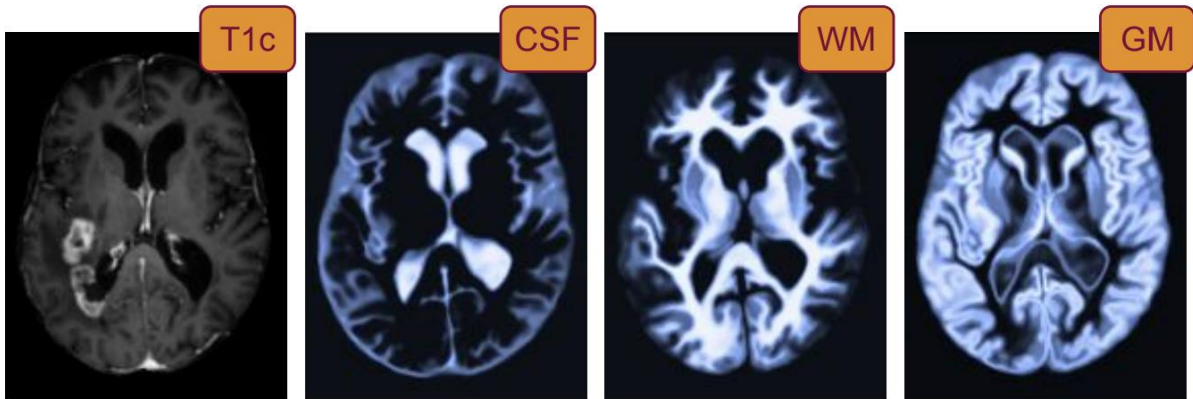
An example of probabilistic tissue segmentation (Cerebrospinal fluid (CSF), White matter (WM), Grey matter (GM)) and corresponding MRI T1c scan. The probabilistic segmentations offer information on the expected tissues underneath and nearby the tumor (from [Ezhov]).
